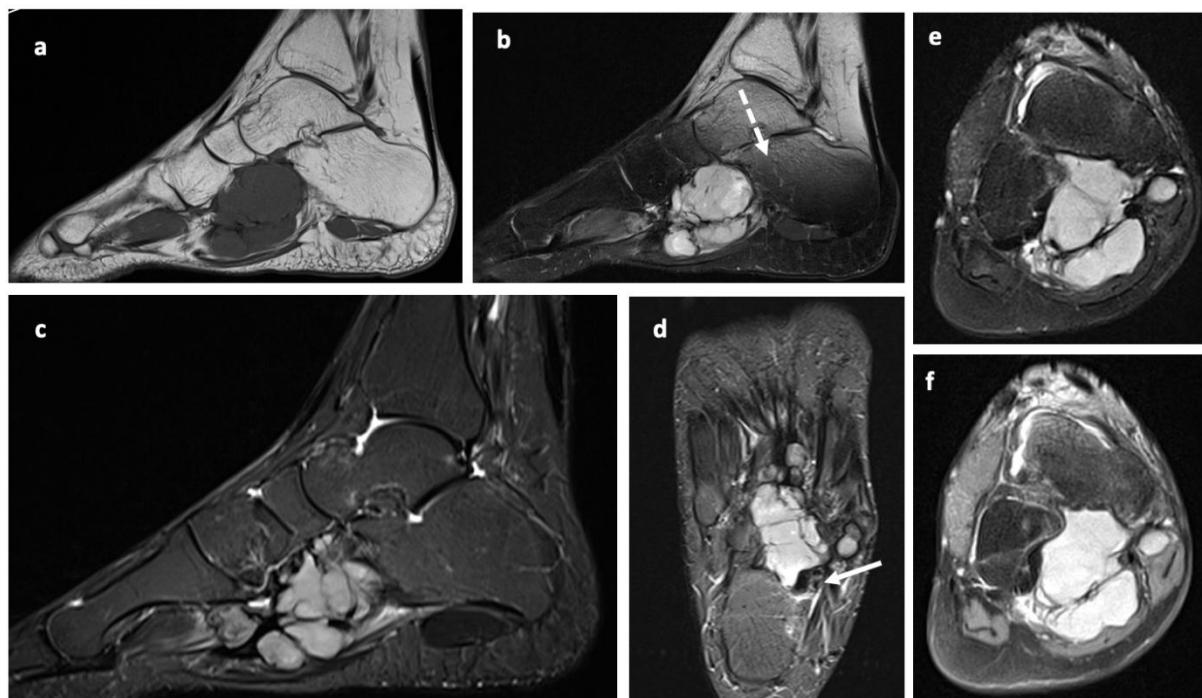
Non-contrast MRI showed a hypointense solid lesion on a) T1WI and b) heterogeneous intensity on T2WI and c) T2 TIRM sagittal view, with partially indistinct borders, lobulated edge on the right plantar pedis, no fat suppression was seen on T2 Fatsat coronal view (f). On T2 TIRM coronal view (d & e), the lesion is a soft tissue origin with no lesion infiltrating into the calcaneal bone (*dashed arrow*) or other tarsal and metatarsal bones without periosteal reaction. No evidence of neurovascular encasement (*arrow*). These results indicated the plantar fascia mass was most likely a fibrosarcoma.
